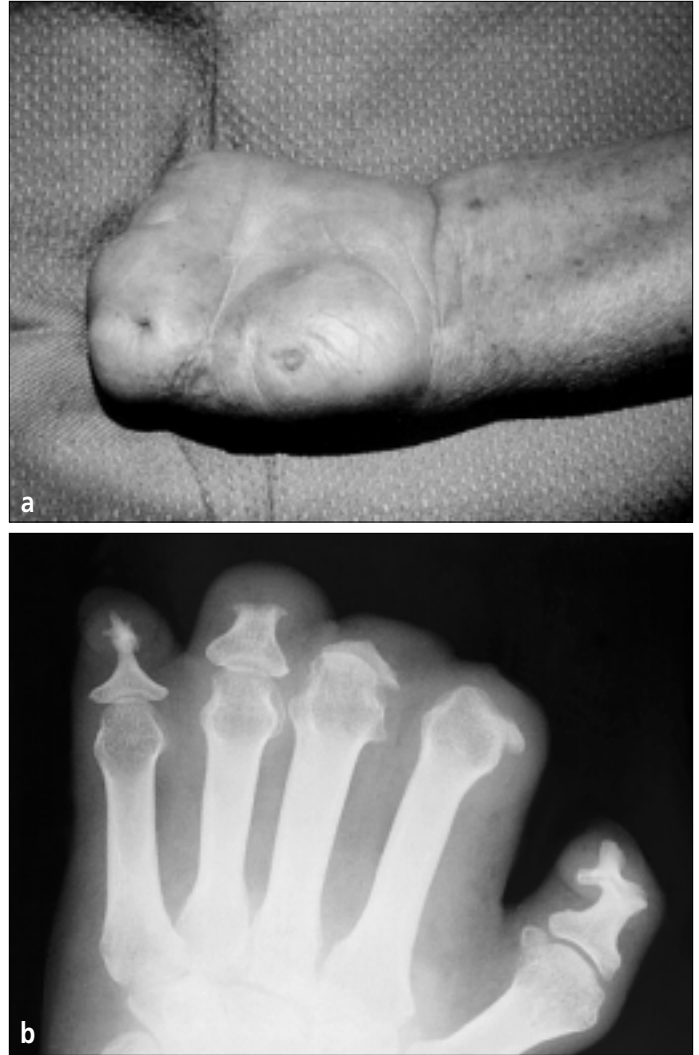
Hansen's disease. (a) Late stage. The fingers have absorbed and only a flipper of a hand is left. (b) X-ray of late stage.
